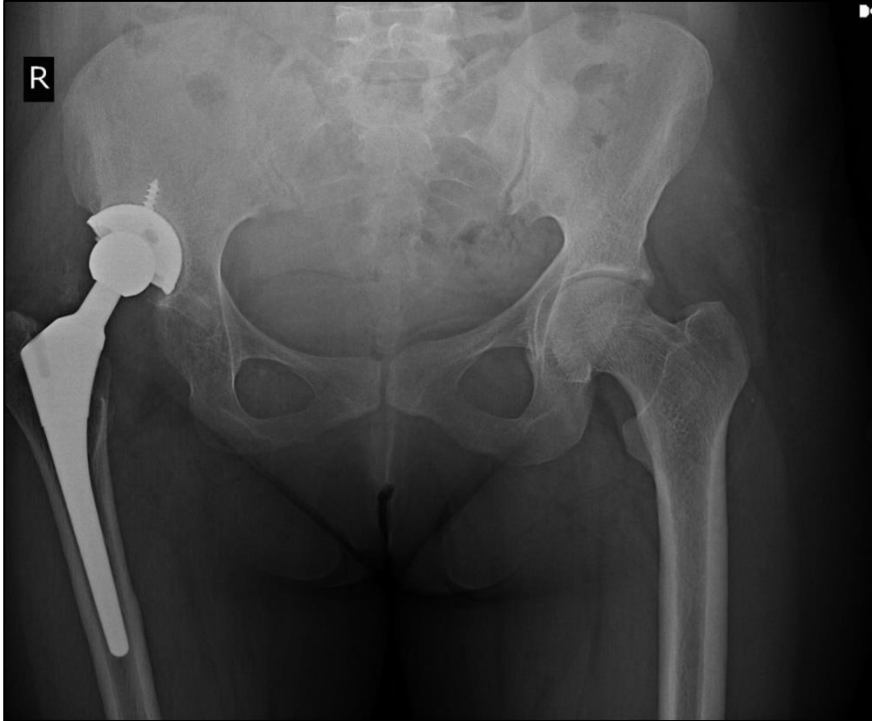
Pelvis x-ray of postoperative 24th months after the total hip arthroplasty, osteolysis of the acetabular cup at first operation at different center
